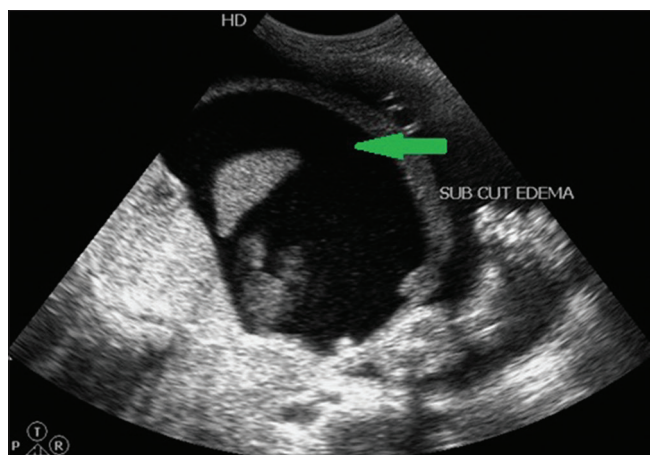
Antenatal ultrasound showing massive ascites (marked with arrow) and subcutaneous edema
